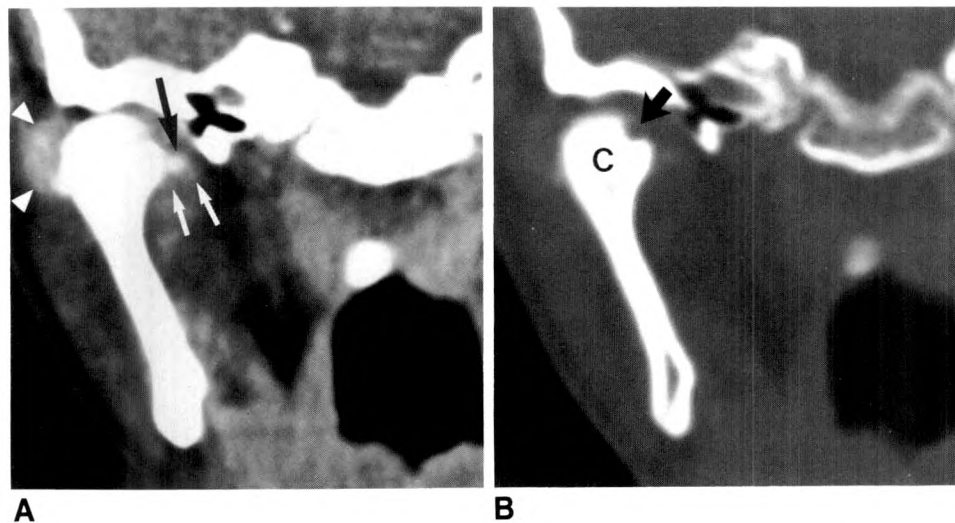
A, Direct coronal CT scan identifies medial (white arrows) and lateral (white arrowheads) margins of dilated joint space. Loose body is seen within far medial joint space (black arrow) adjacent to medial condylar-head erosion.
